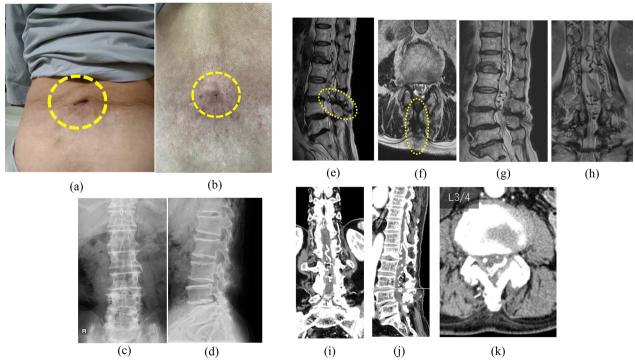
Preoperative photograph of the patient's back and radiological findings of the lumbosacral spine. (a, b) Patient exhibited a skin ostium (dotted circle) in the medial lumbar region. (c, d) Radiographs of the lumbar spine showing spondylosis without other abnormalities. (e, f) A continuous ductal structure (dotted ovals) observed from a skin ostium appearing to run deeply toward the L3/4 interspinous process, terminating at the dural surface and entering the thecal sac. (g, h) Tortuous intradural flow voids were apparent along surfaces of the spinal cord from the lower thoracic to lumbar spine. (i, j) Enhanced computed tomography showing enlarged tortuous veins from L4 to T12, with filling in the early arterial phase. (k) We observed a mixture of thin and thick contrasted veins at the L3/4 level
